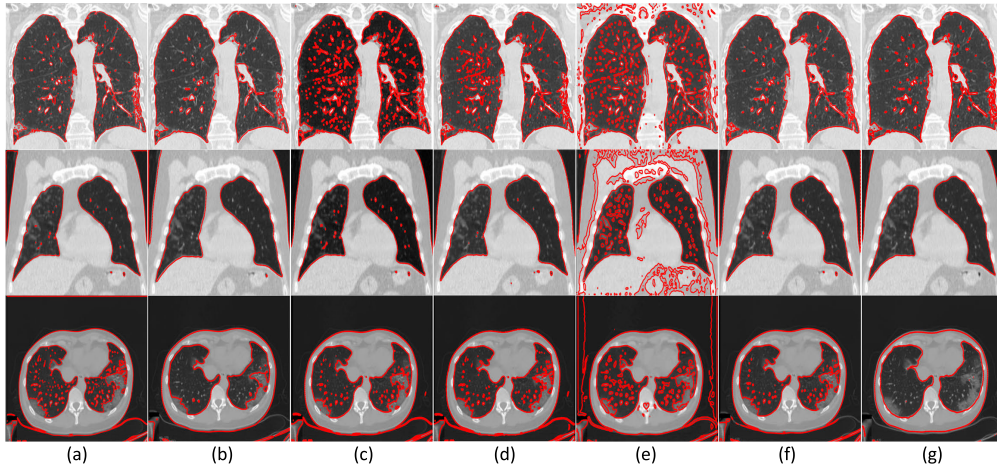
Segmentation and comparison of COVID-19 patient's lung CT from [41]. (a) CV, (b) LBF (c) VLSBCS, (d) LSACM, (e) LGFI, (f) McGKFCM, and (g) Proposed SalCor.
